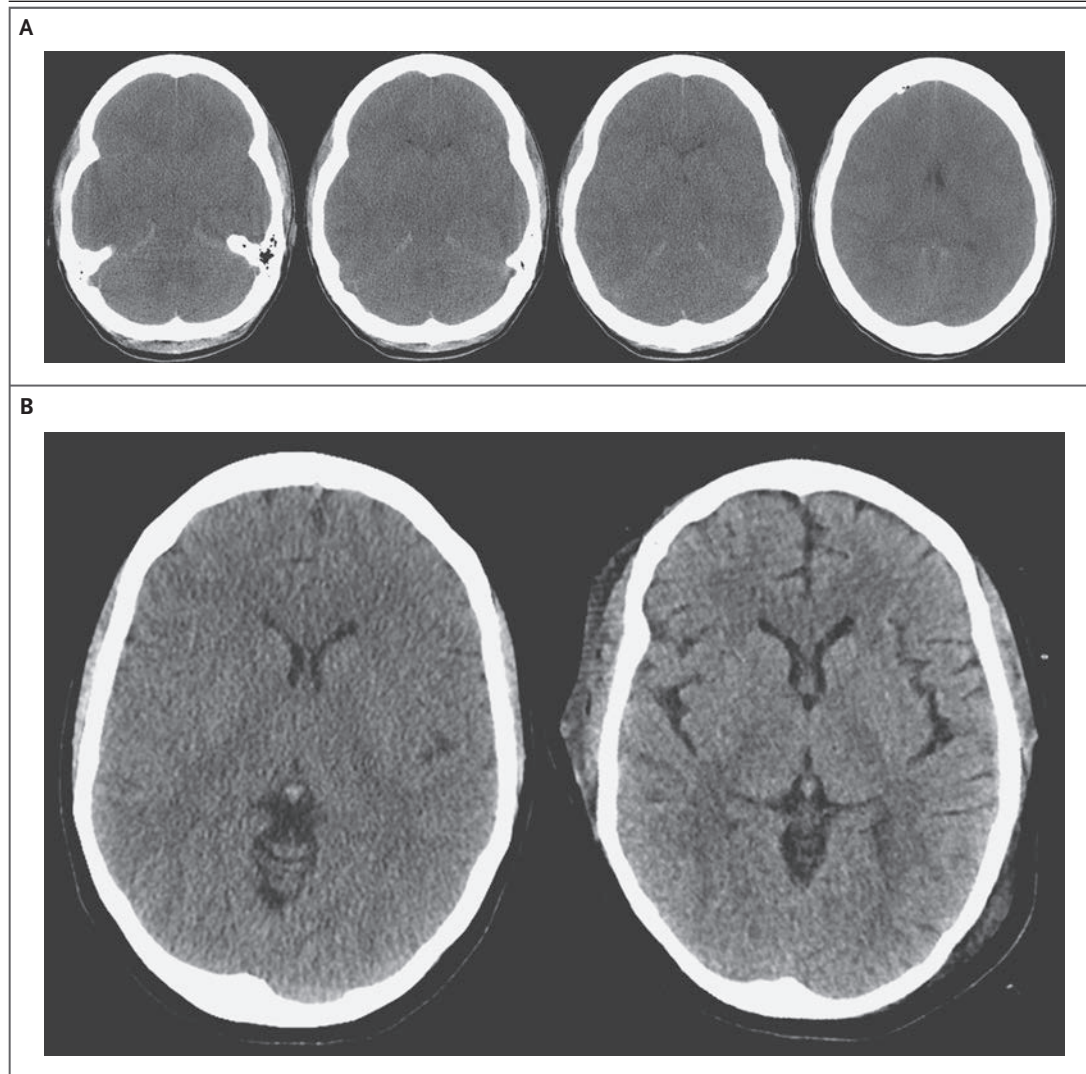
CT Findings in Fulminant Hepatic Failure.
